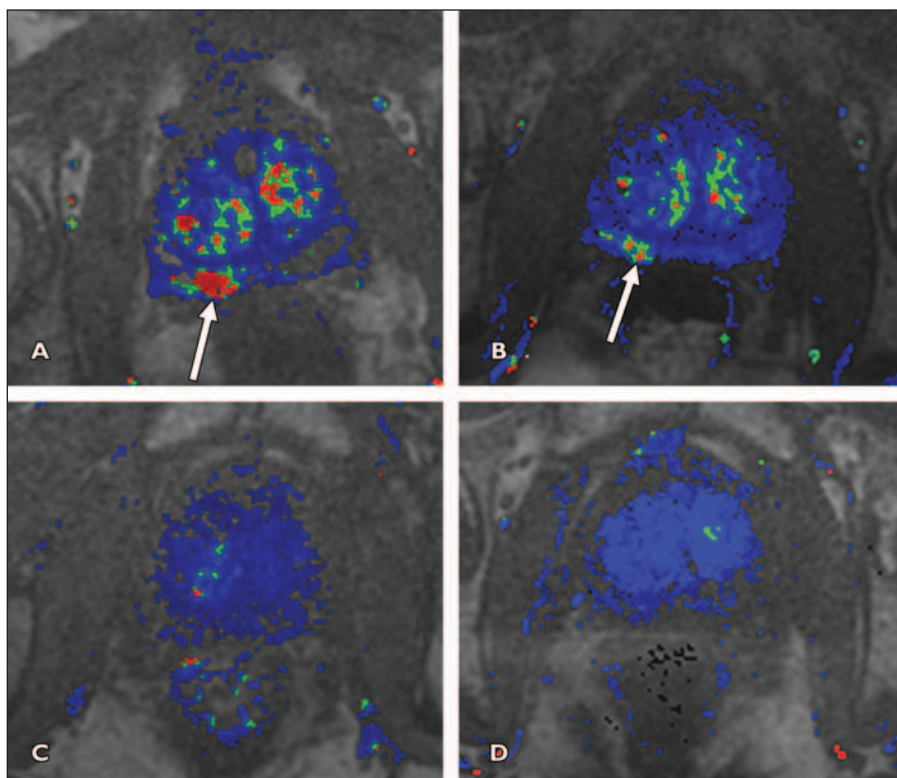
78-year-old man with biopsy-proven Gleason 9 right-sided prostate cancer and 24-month clinical and MRI follow-up results.
